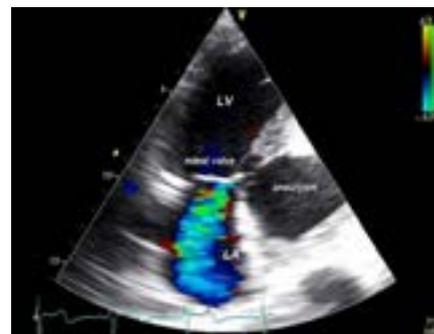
Severe mitral insufficiency revealed on transthoracic echocardiography apical two-chamber view.
